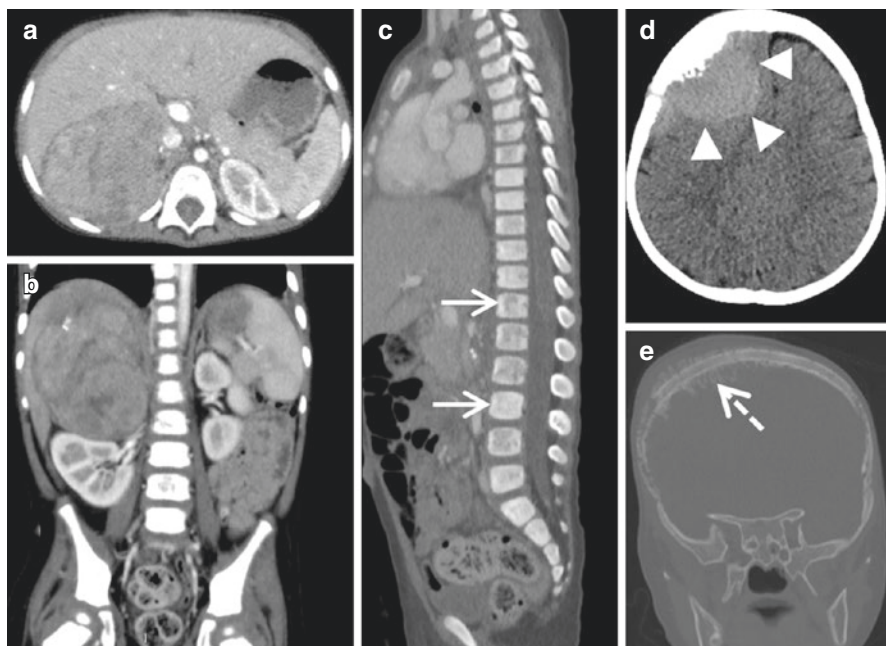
A 27-month-old boy with metastatic abdominal neuroblastoma (MYCN non-amplified, segmental chromosome alteration, INSS stage 4, INRGSS M). Contrast-enhanced transverse CT scan (a) and coronal (b) views of the abdomen, sagittal (c) view of the spine and transverse (d) and coronal (e) views of the brain and skull. The primary tumour arises from the right adrenal gland (a, b). Spinal bone and bone marrow metastases (c) are depicted by CT which demonstrates both decreased and increased density areas (arrows). Skull metastases (d, e) typically occur around the coronal fissure: the right frontal and parietal bones appear heterogeneous with cortical destruction and spiculated periosteal reaction (dotted arrows). In this patient, intracranial soft tissue invasion crosses the dura and directly invades the frontal lobe (arrowheads)
